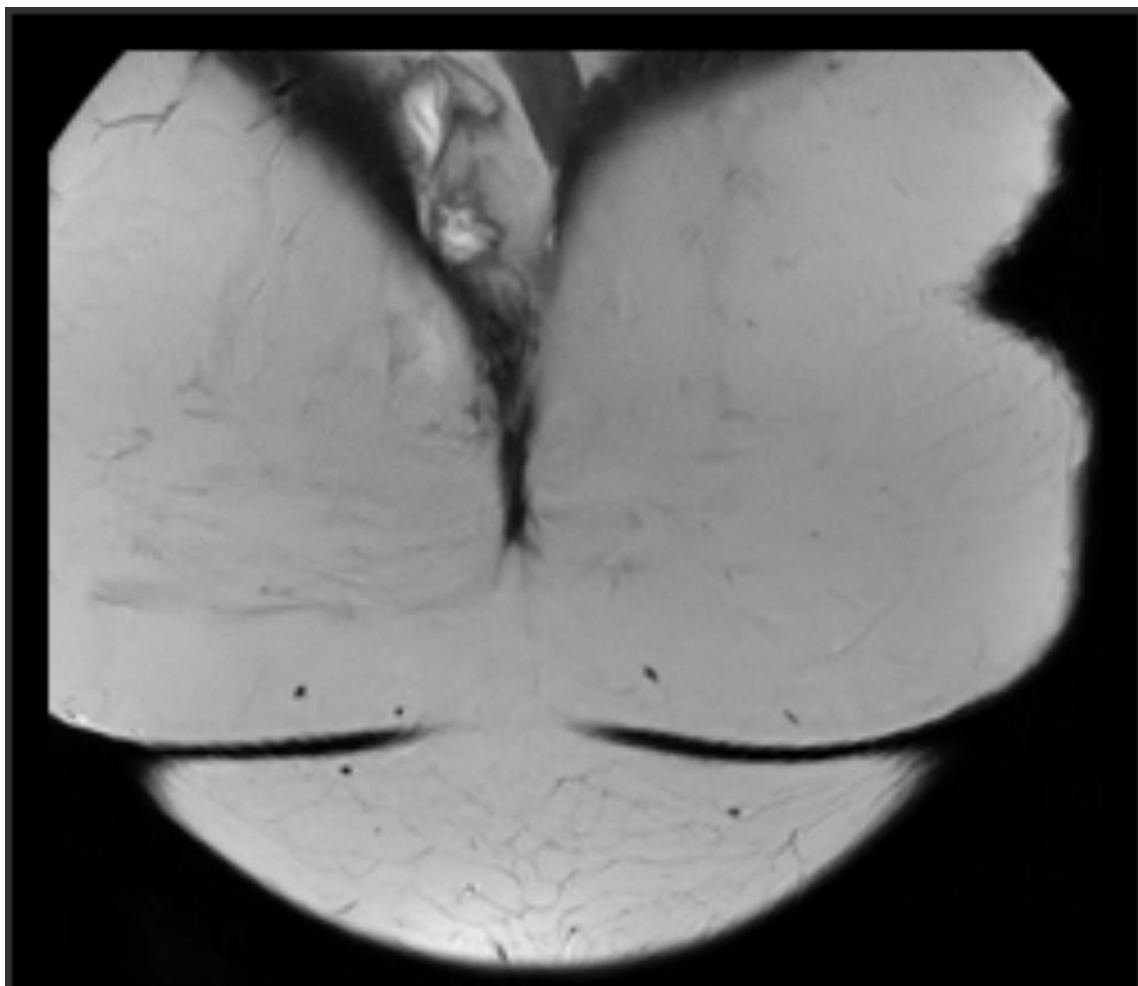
Pelvic MRI; lesions on the vulva
